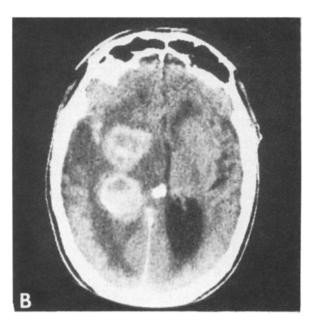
CT scan without (A) and with (B) contrast medium, demonstrating the extent of a metastatic hypernephroma lesion. C, CT scan without contrast immediately after radiation therapy, demonstrating reduction of the brain lesion noted in A and B.
